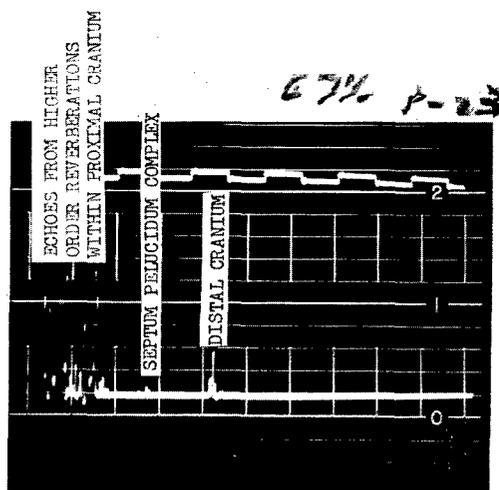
Ultrasonogram of Transcranial Scan Prior to Injection of Air into Carotid Artery.
